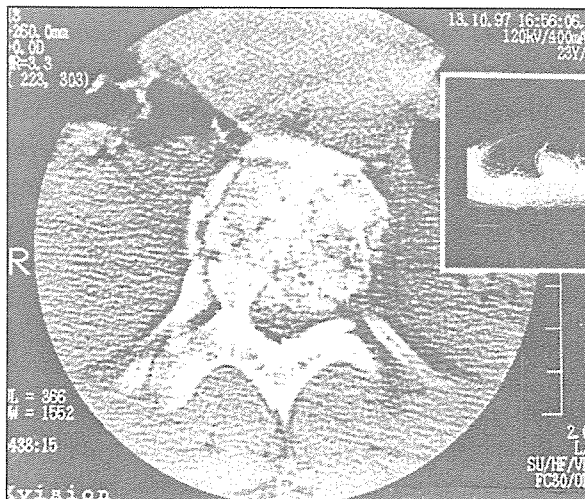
Preoperative (a) and postoperative (b) CT images of the patient. The images were taken at the same level. Minimally displaced comminuted corpus fracture, intact right pedicle and intact posterior elements can be demonstrated.
